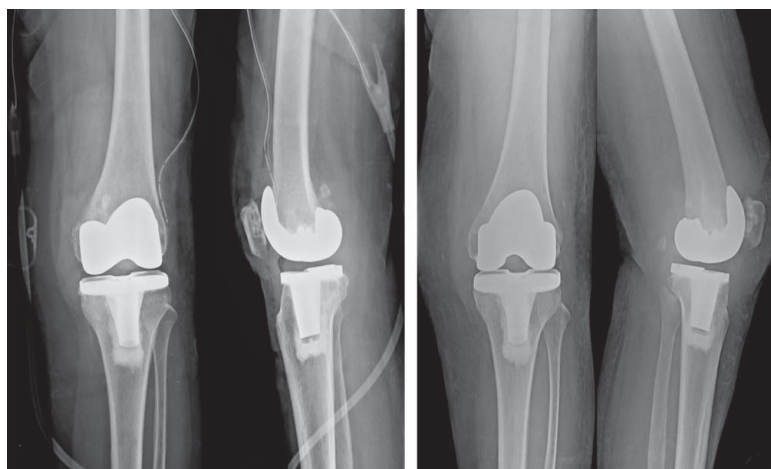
The post-operative plain film showed good prosthetic position (left). One month follow-up, there was no loosening of prosthesis (right).
